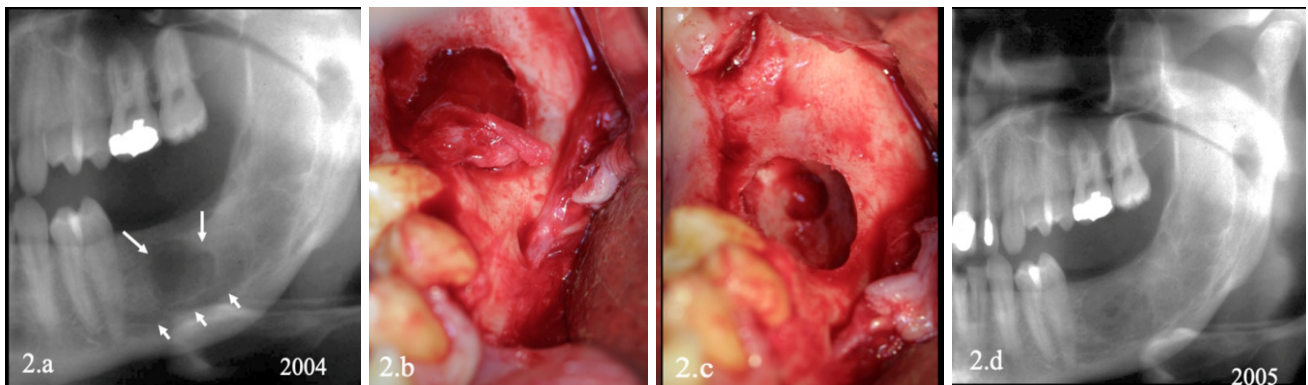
a. Two-years (2004) cropped panoramic radiograph showing a mono-ocular radiolucency (→) and the mandibular canal still in a basilar position (→). b. Enucleation of the lesion, the mental nerve was intact. c. The bony cavity after enucleation and note the small inside bony cavity. d. One-year (2005) cropped panoramic radiograph showing the bone healing of the lesion after second surgery.
